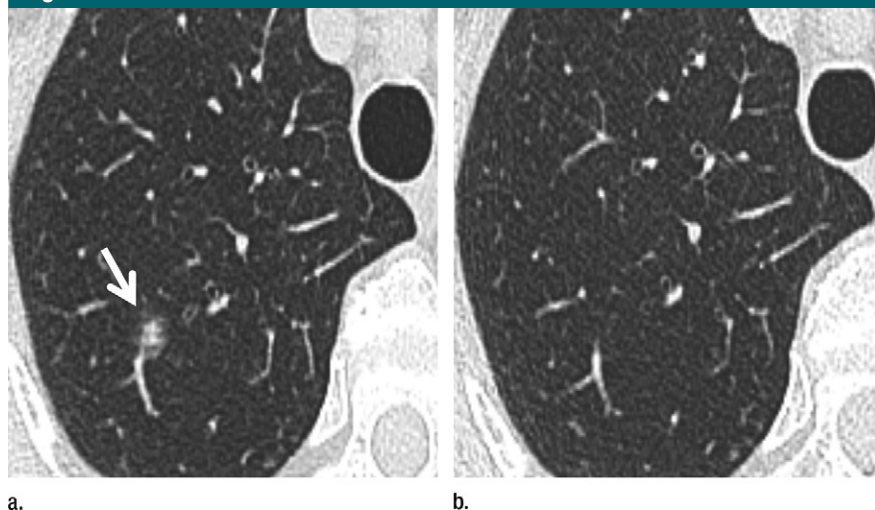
(a) Transverse 1-mm CT section through the right upper lobe shows a 6-mm part-solid nodule with a solid component (arrow) smaller than 4 mm. (b) Follow-up CT section at 6-month follow-up shows complete resolution, consistent with a benign cause.
